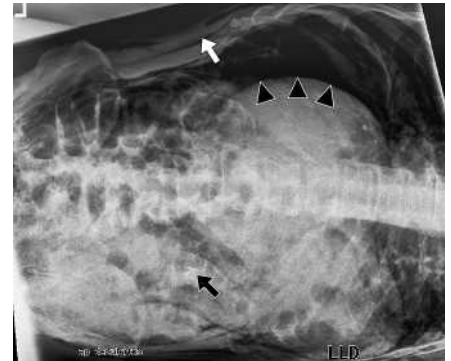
Abdominal radiograph taken in the left-lateral position 2 hours after polypectomy, showing two clips at the polypectomy site (black arrow), subcutaneous emphysema (white arrow), and intra-abdominal air between the left abdominal wall and the liver (arrowheads).
